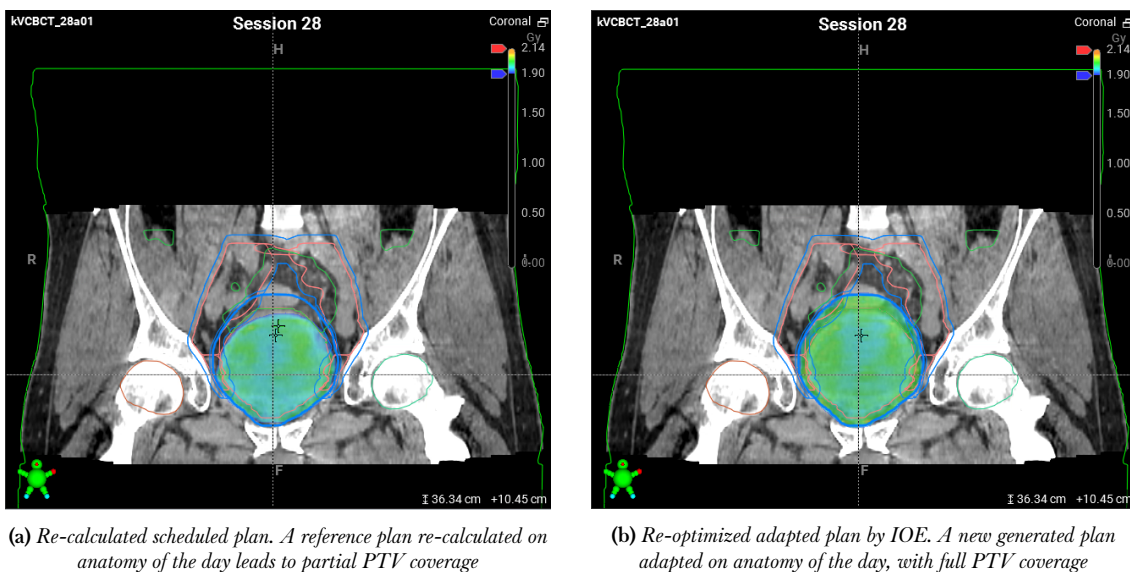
Dose color-wash on axial CT slice, fraction 28 of a bladder cancer patient treated with oART, demonstrating the PTV high dose coverage for scheduled (6a) and adapted (6b) plan generated on Ethos TPS on-couch.
